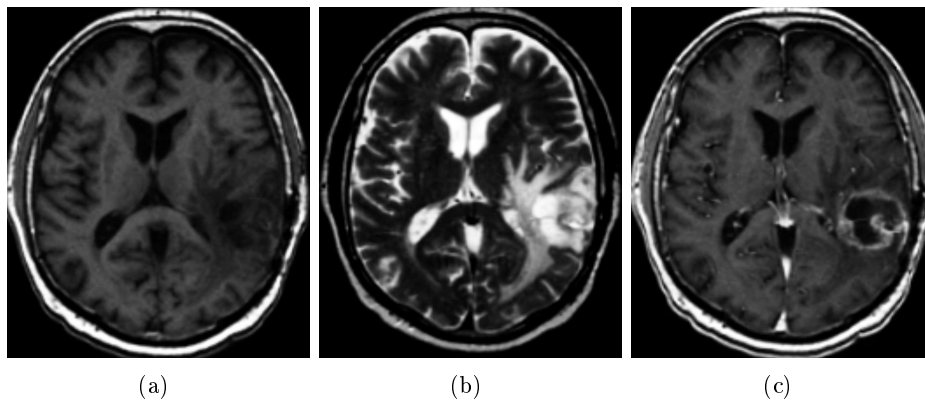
In the images above we show axial slices of (a) T1-weighted, (b) T2-weighted and (c) T1-weighted post gadolinium injection images of a patient suffering from a grade IV glioma, glioblastoma multiforme. The appearance of GBM is very irregular in the MR images.
